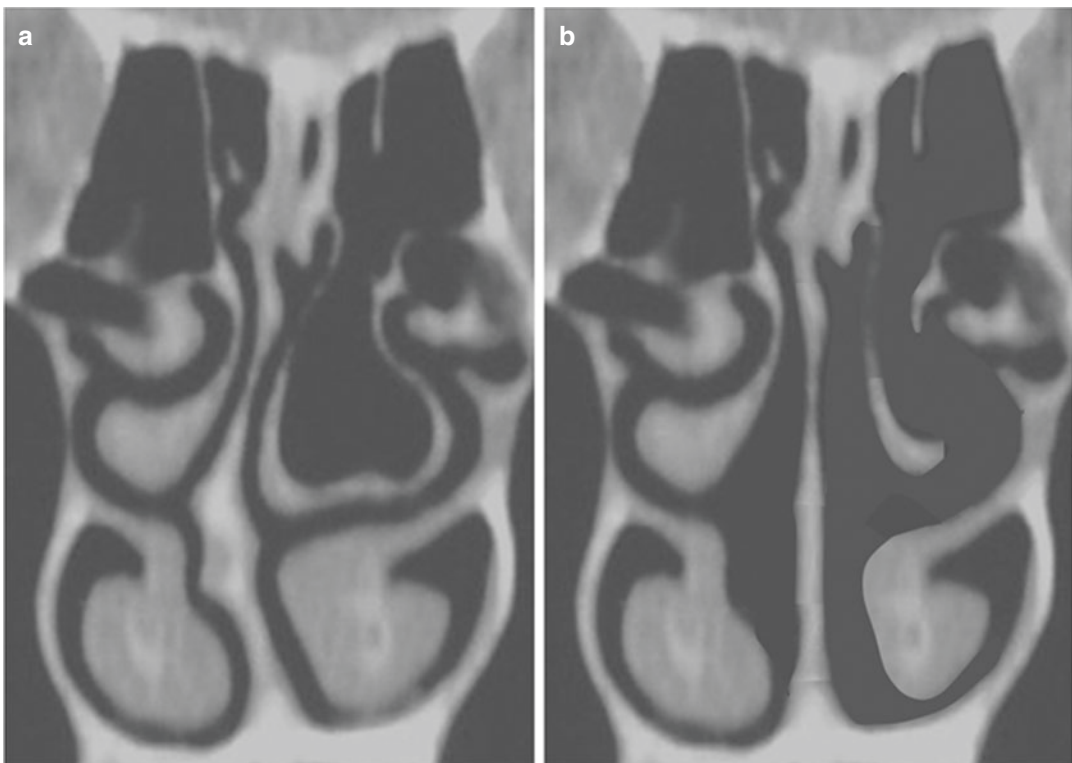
(a) Coronal CT scan through the middle of the nose of a patient with a pre-pubertal septal deviation. Since there is no constriction in the slit-shaped space, it is a physiological septal deviation. (b) Imitated complete
